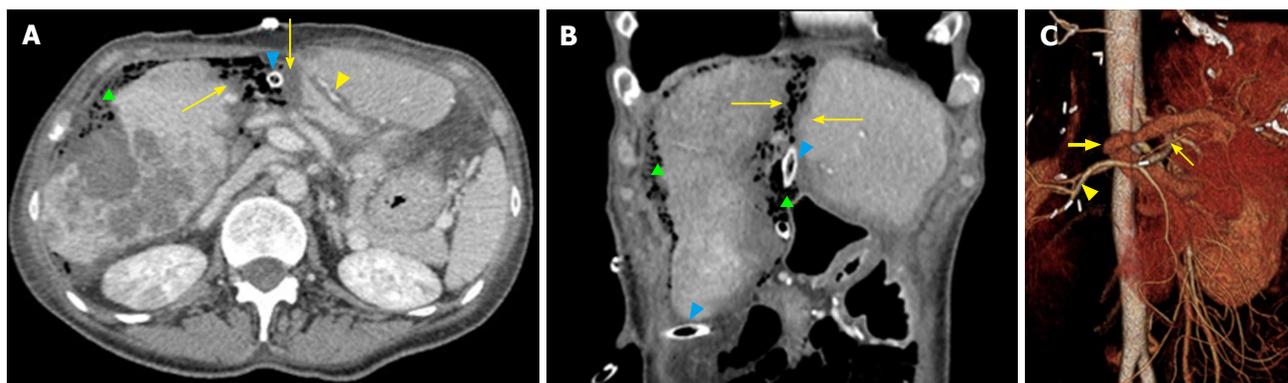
Normal findings on computed tomography after stage 1 surgery on transverse (A) and coronally-reformatted images (B), as well as volume rendering 3D reconstruction (C) (right trisectionectomy associating liver partition and portal vein ligation for staged hepatectomy). A thin rim of free fluid with air bubbles is visible along the surface of diseased hemiliver (right liver lobe), suggesting its accumulation within the plastic bag (green triangle on A and B). A similar finding can be appreciated along the line of transection. Mild periportal edema (yellow arrowhead in A), thin hypodense bands along the edges of surgical resection (arrows on both A and B) and drains (blue arrowheads) are visible. Main right portal branch was ligated and transected (thick arrow in C). Hepatic artery branches are patent (C), including right hepatic artery, which shows mild hypertrophy (arrowhead), and left hepatic artery (thin arrow).
